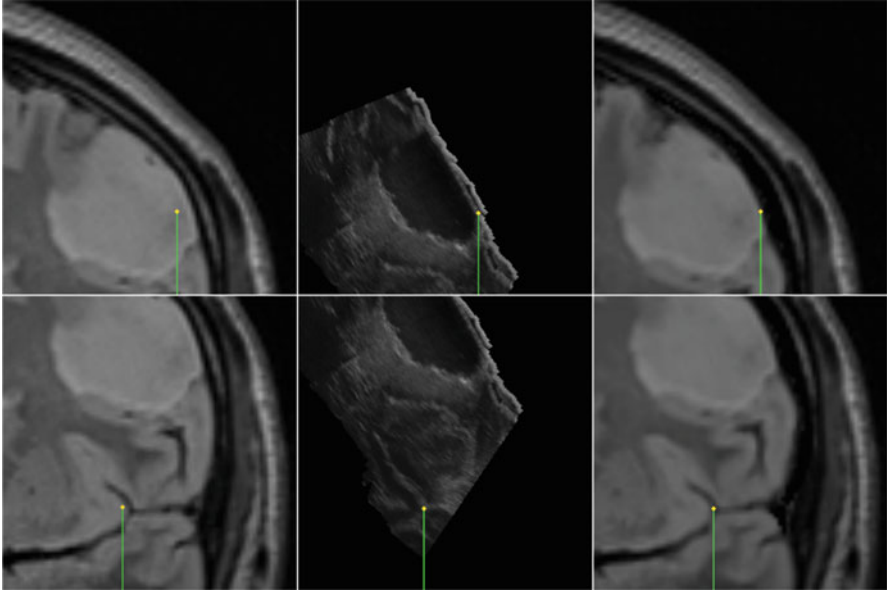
Brain shift compensation during resection for patient 1 using the constraint-based biomechanical method. Slices of the pre-operative MRI, B-mode ultrasound image, and updated MRI are shown. A pointer first shows the borders of the exposed cortical surface (top row) then a deep sulcus bifurcation point (bottom row)
